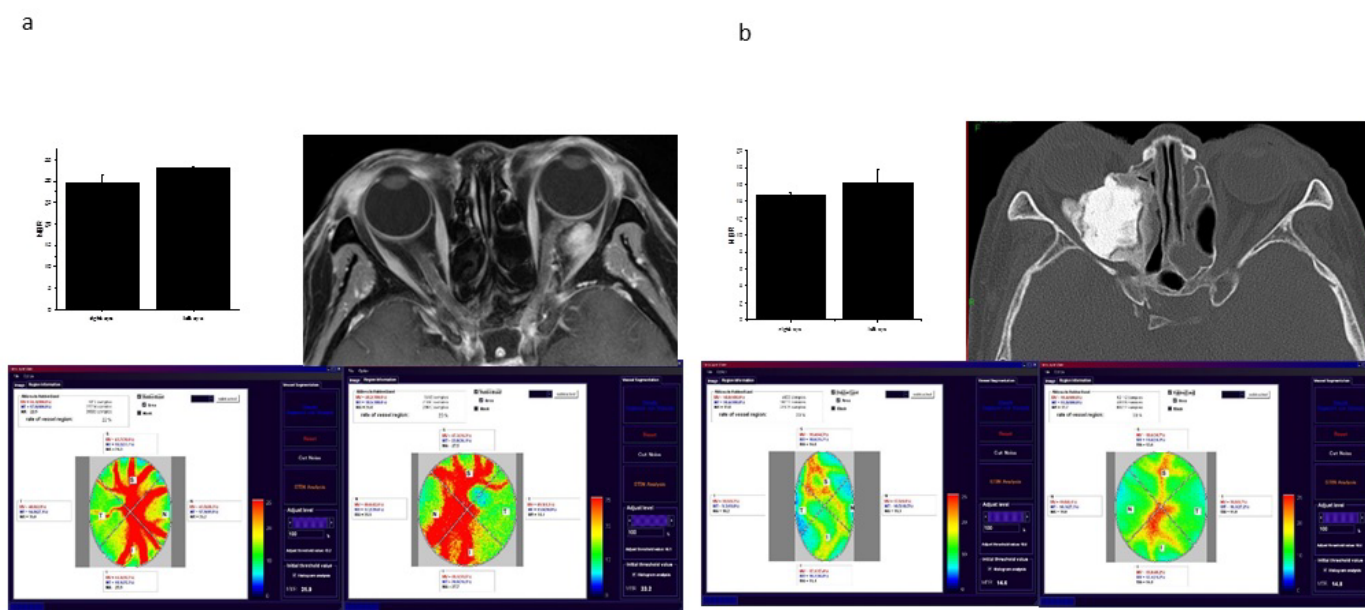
(a) Case 3: Mean MBR: right eye; 29.5 ± 2.08 , left eye; 33.1 ± 0.32 (top left). Orbital MRI (top right). Representative LSFG of the right (bottom left), and left eye (bottom right). (b) Case 4: Mean MBR: right eye; 14.8 ± 2.42 , left eye; 25.7 ± 1.65 (top left). Orbital MRI (top right). Representative LSFG of the right (bottom left), and left eye (bottom right).
